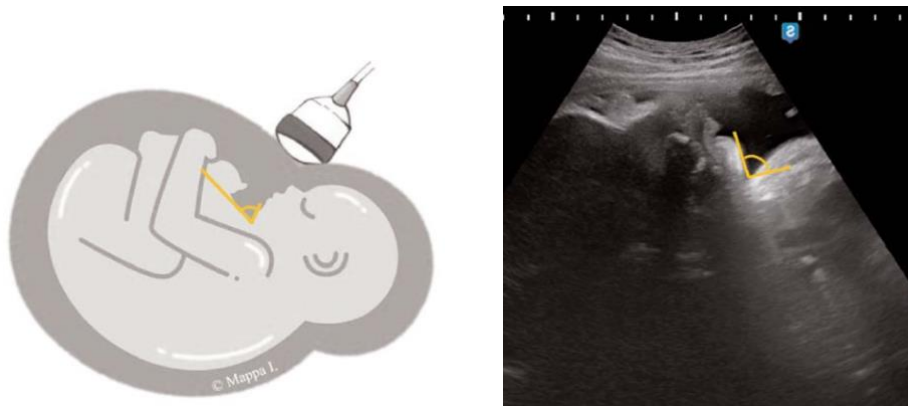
Measurement of chin-to-chest angle in fetuses with occiput posterior position and corresponding ultrasound image (Adapted from *Ultrasound in labor: clinical practice guideline recommendation by the World Association of Perinatal Medicine (WAPM) and the Perinatal Medicine Foundation (PMF)*)¹
